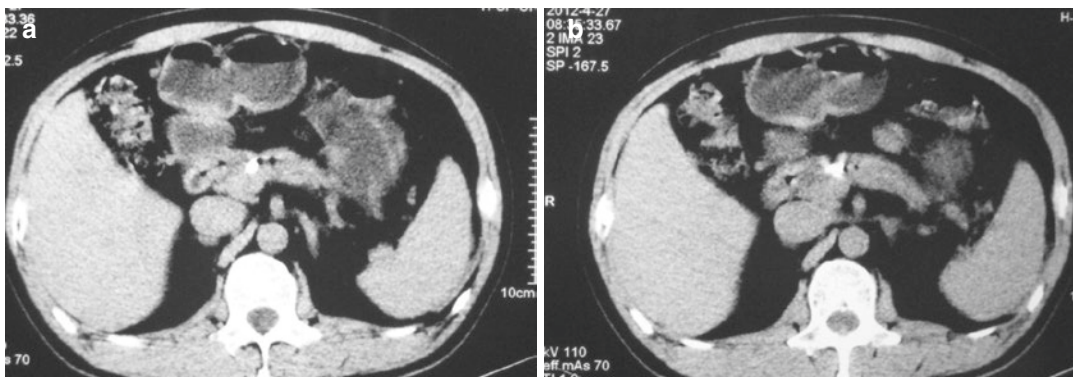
CT revealed a decrease in the volume of the pseudocyst, atrophy in the pancreatic body and tail, and the post-ERCP pancreatic duct after stent placement
